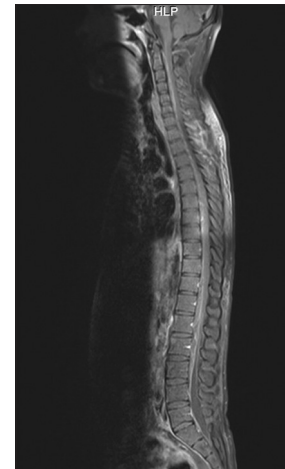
Magnetic resonance imaging whole spine
